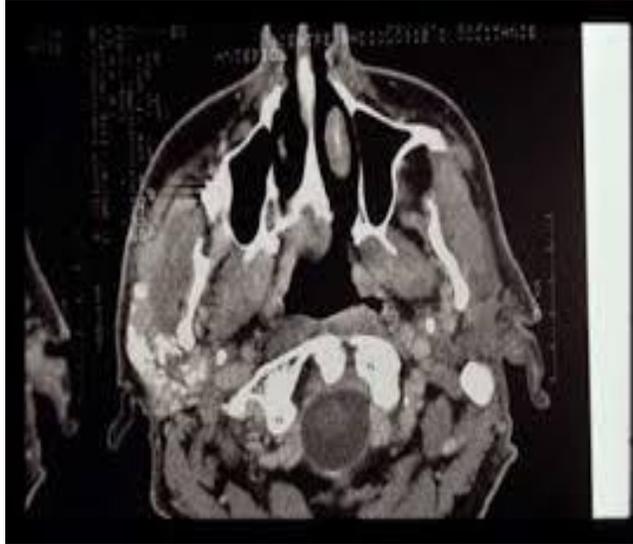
CT scan showing the right parotid mass with suspected perineural invasion
